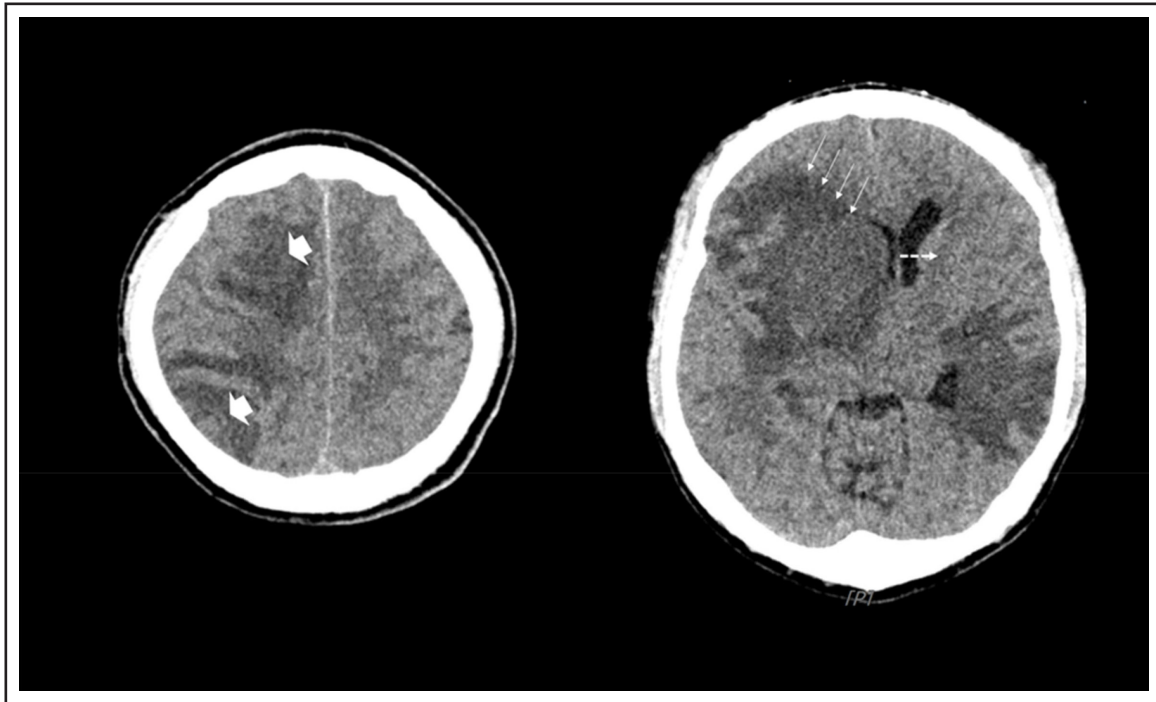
Axial plain CT Brain showing ill-defined lesions associated with perilesional oedema (thick arrow) and extensive mass effect (thin arrow) onto the right lateral and third ventricles resulting in obstructive hydrocephalus and significant midline shift (dashed arrow).
